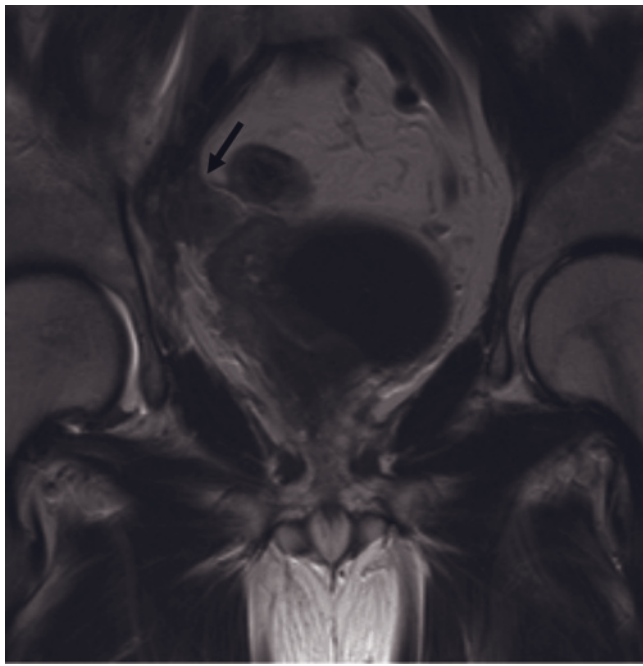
Transitional cell cancer, advanced disease. T2-weighted spin-echo (*a*), T1-weighted gadolinium-enhanced fat-suppressed spin-echo (*b*), and T1-weighted postgadolinium SGE (*c*) images in a patient with T4bN1M0 transitional cell carcinoma. A large cancer arises from the left and posterior aspect of the bladder (black arrows, *a*). Invasion of the obturator internus muscle is shown (large arrow, *a*). The tumor enhances heterogeneously after gadolinium administration (thin white arrow, *b*). Tumor extension into the obturator internus (small arrows, *b*) is relatively high in signal intensity compared to muscle. Thrombus in the right common iliac vein is identified (large arrow, *b* and arrow, *c*). A Foley catheter is present in the bladder (*c*). T1-weighted gadolinium-enhanced fat-suppressed (*d*) image in a second patient with deeply invasive transitional cell cancer. The tumor invades the posterior wall of the bladder. Deep invasion is evidenced by irregular enhancing tissue that extends through the full thickness of the bladder wall (arrow, *d*). Sagittal (*e*) and transverse (*f*) T2-weighted single-shot echo-train spin-echo and sagittal (*g*) and transverse (*b*) T1-weighted gadolinium-enhanced fat-suppressed images in a third patient with high-grade invasive transitional cell carcinoma. The bladder wall is diffusely thickened and irregular (*e*, *f*), with moderately intense enhancement after gadolinium
